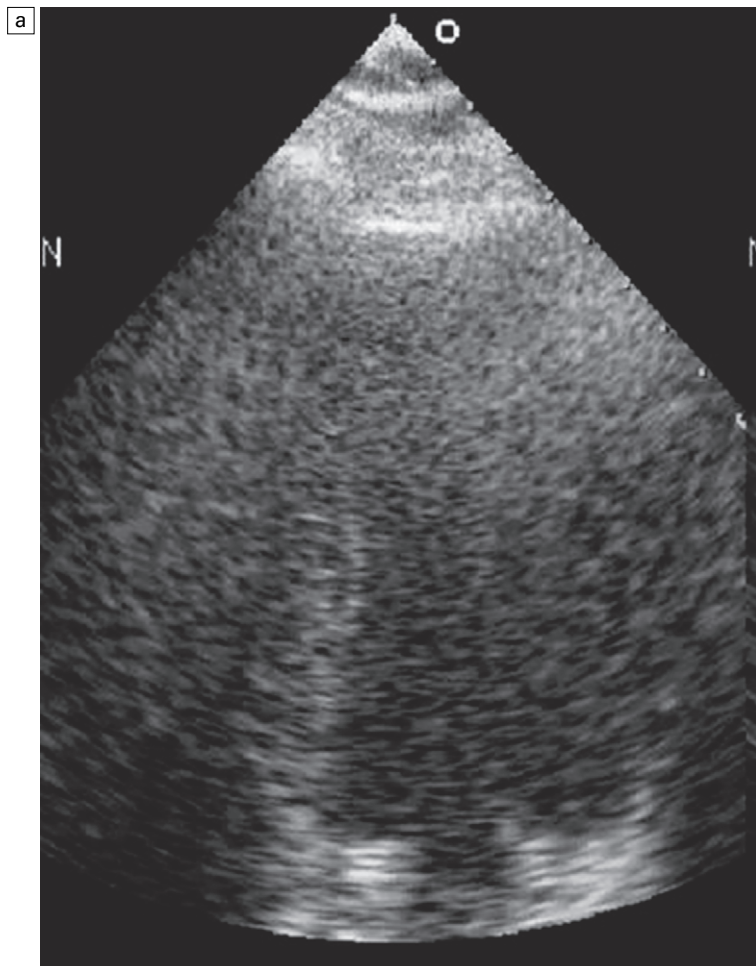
Apical four chamber view using tissue harmonic imaging (a) in an intensive care unit patient with very poor imaging windows. The patient had been recovering slowly post cardiac surgery and the request was to assess left ventricular function (LV) function. Image quality was so poor that no comment could be confidently made about LV function.
